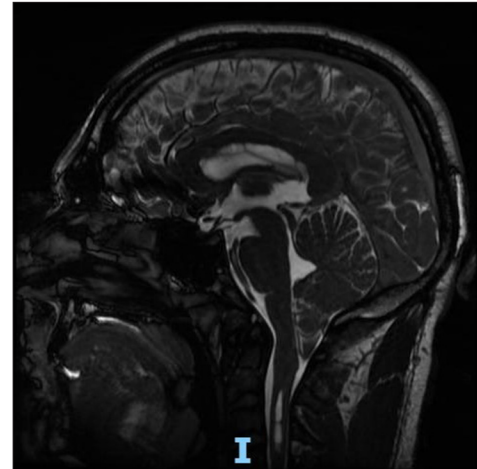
Preoperative T2-weighted sagittal magnetic resonance imaging showing 17 mm descent of the cerebellar tonsils and syrinx extending from C3 to C4. The “I” in CM-I stands for “Chiari type I malformation”.
